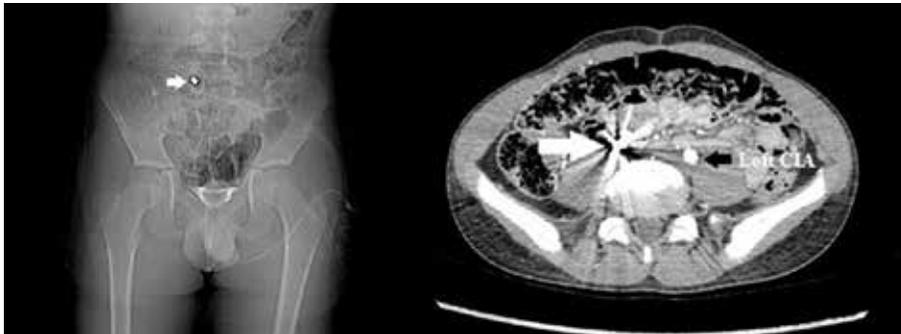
Chest radiograph with radiopacity (pellet) in the abdomen. Computed tomography showed migration of the pellet in the likely location of the right common iliac artery.
